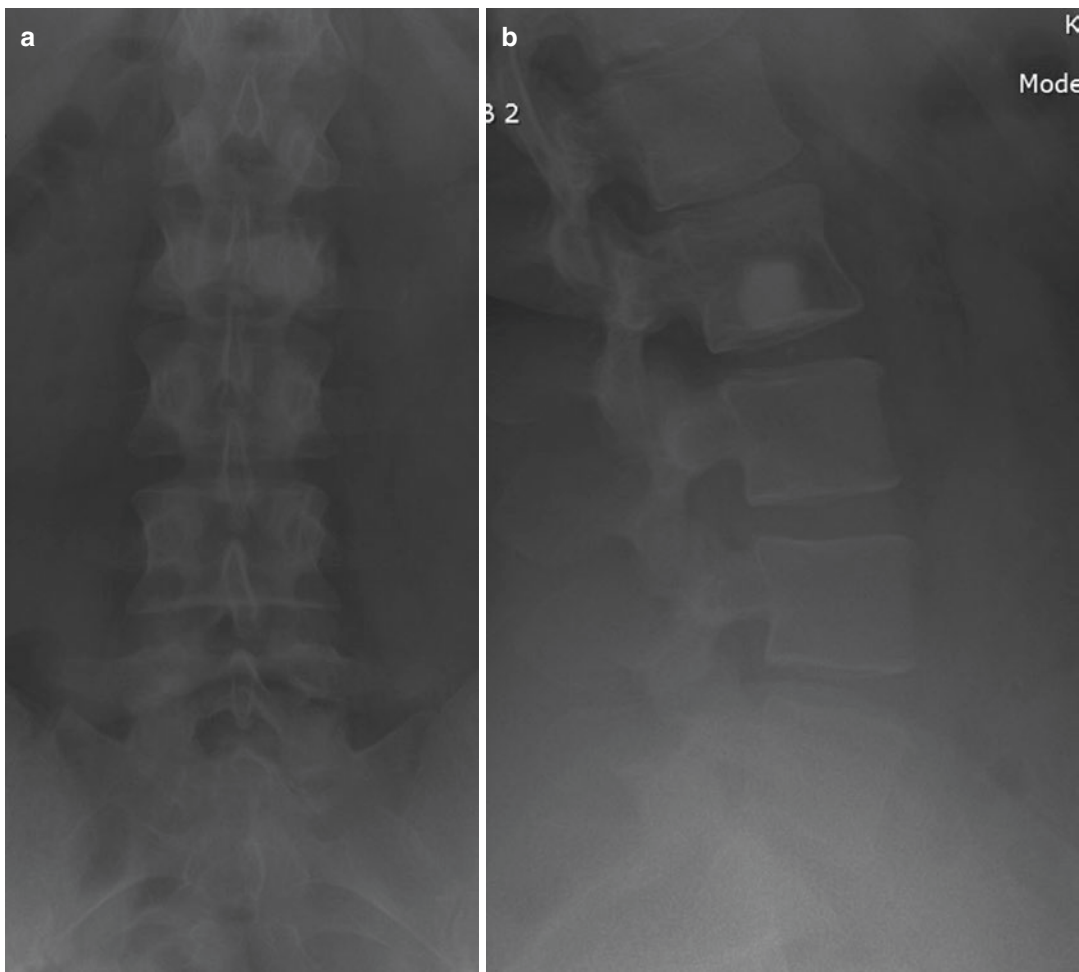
The postoperative standing lumbar radiographs following tumor excision and cementation (a: anteroposterior, b: lateral)
